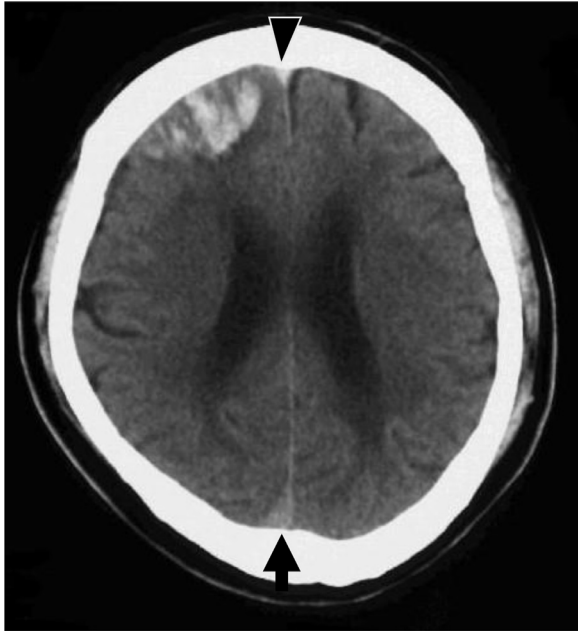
Unenhanced CT at admission at day 0. Unenhanced CT image showed subcortical intracerebral hemorrhage with surrounding edema in the right frontal lobe. Hypertensive intracerebral hemorrhage was diagnosed at another hospital. Under our retrospective review, a high attenuation (arrowhead) suggesting thrombosis at acute phase is detected in the anterior portion of superior sagittal sinus. While, the posterior portion of SSS shows a normal ranged attenuation (CT value: 23 HU) (arrow).
